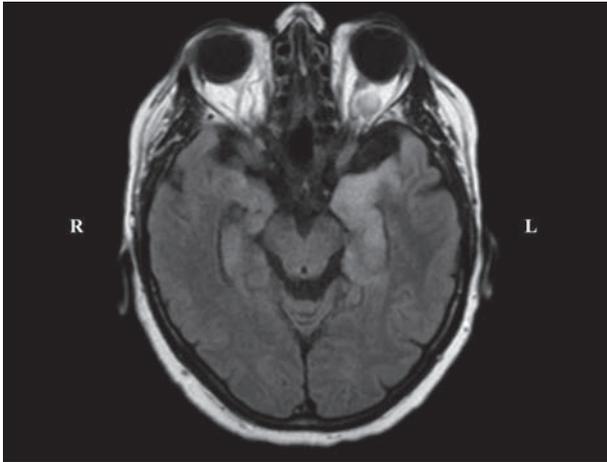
3T Brain MRI: Axial FLAIR sequence, hyperintensity of left temporo-polar and mesio-temporal lobe. R: right; L: left
